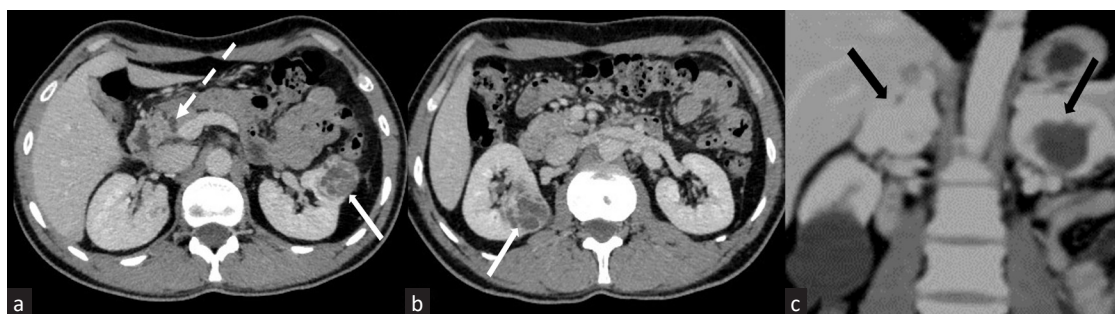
Contrast-enhanced CT images of a 34-year-old man with VHL. (a-b) Bilateral complex renal cystic lesion with heterogeneously enhancing solid internal components: renal cell carcinoma (solid white arrows) with nonenhancing subcentimeter hypodense lesions of cystic attenuation in the pancreatic head; simple pancreatic cysts (dashed white arrow). (c) Heterogeneously enhancing soft tissue density mass with hypodense internal areas involving bilateral adrenal glands: pheochromocytomas (black arrows). CT: Computed tomography, VHL: Von-Hippel-Lindau.
